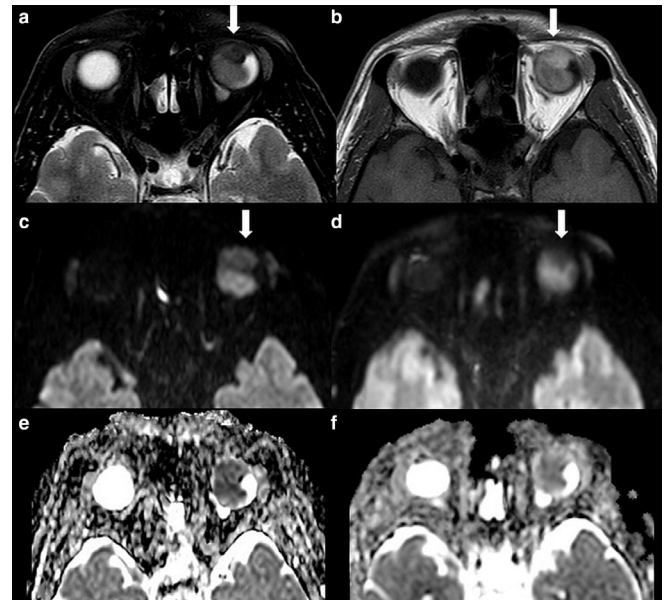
Bilobulated heterogeneous intraocular mass has an anterior part (arrows) which is more hypointense on T2WI (a) and more hyperintense on T1WI (b). Anterior tumor component with more profound T2 hypointensity shows relatively low signal intensity on both ssEPI-DWI (c) and ssTSE-DWI (d), more prominent on ssTSE-DWI. The lesions are visually homogeneous on ADC maps (e, f).
